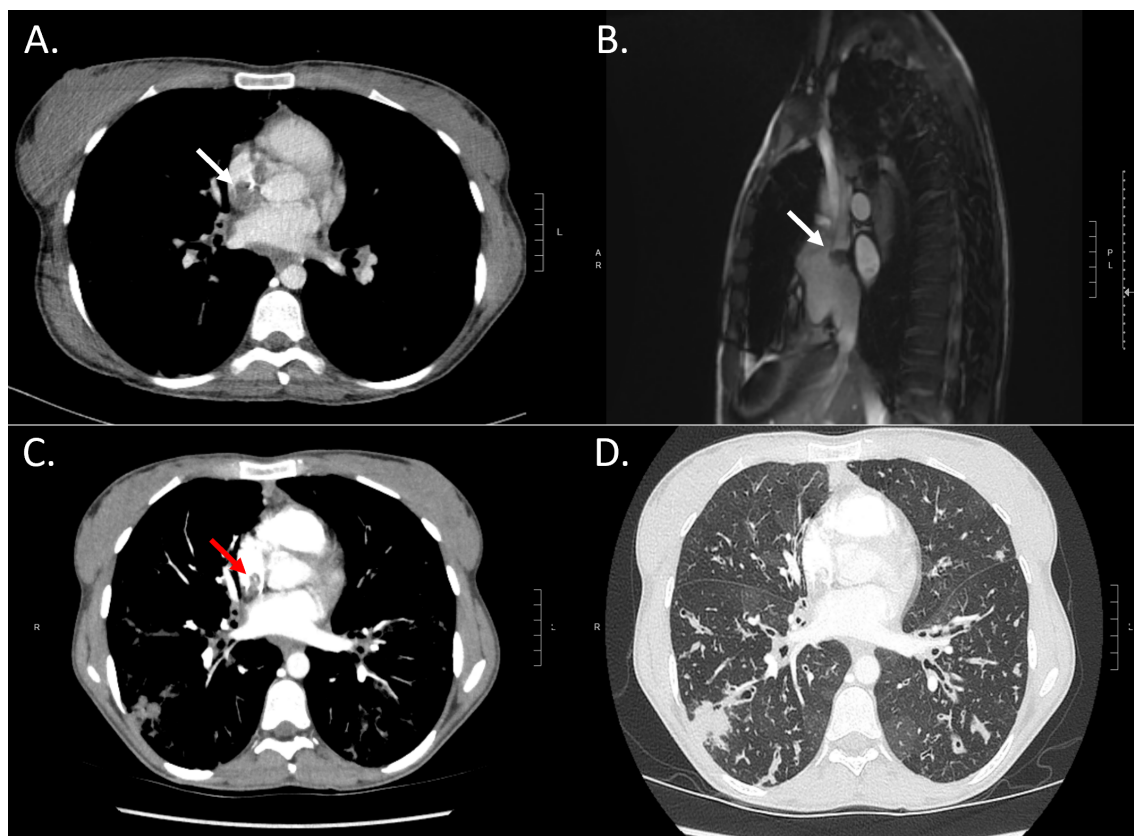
(A) Computed tomography chest highlighting retained totally implantable venous access devices (TIVAD) segment with associated filling defect (white arrow) at the tip. (B) Cardiac MRI highlighting the same retained TIVAD segment with associated thrombus (white arrow) appearing adherent to the posterior surface of the right atrium. (C) CT pulmonary angiogram (CTPA) showing lobulated superior atriocaval junction thrombus (red arrow) with right lower lobe subpleural multifocal consolidation associated with right lower lobe segmental and left lower lobe subsegmental pulmonary emboli (PE). (D) CTPA lung windows highlighting subpleural consolidation and underlying bronchiectasis.
